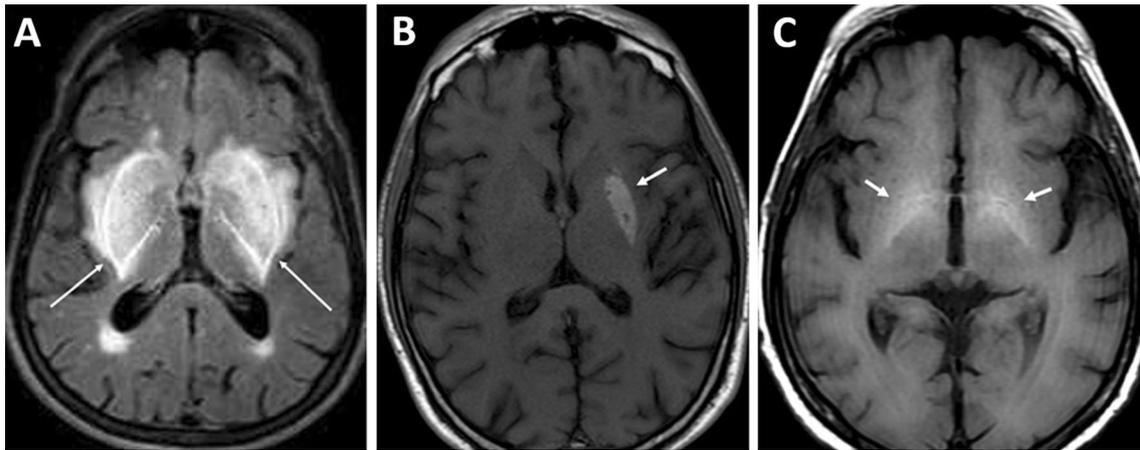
Neuroimaging of selected metabolic disorders (1/2). Axial FLAIR brain MRI shows bilateral symmetrical hyperintense signal in the basal ganglia that delineate the lentiform nucleus (fork sign) (a), characteristic of metabolic acidosis. Axial T1-weighted brain MRI shows hyperintense signal in the left striatum in a patient with right-sided hemichorea/hemiballismus due to non-ketotic hyperglycemia in a patient (b).
